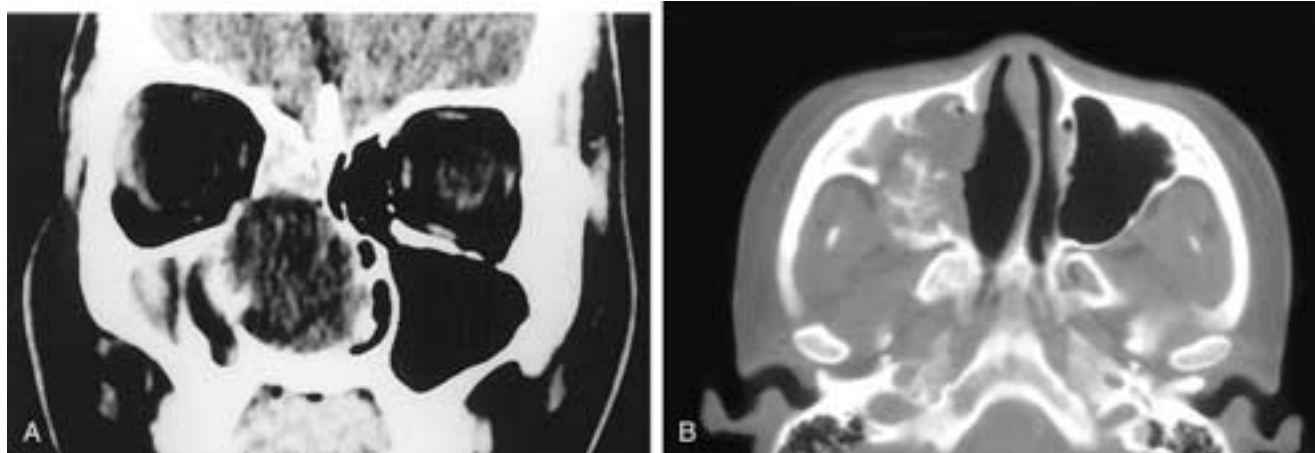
Coronal CT scan (A) shows a mucoid attenuation mass expanding the right nasal fossa. Bony thickening is present along the adjacent right nasal vault wall. Axial CT scan (B) taken after biopsy of the mass shows irregular tumoral bone within the right antrum bulging into the infratemporal fossa. This patient had a primitive neuroectodermal tumor.
